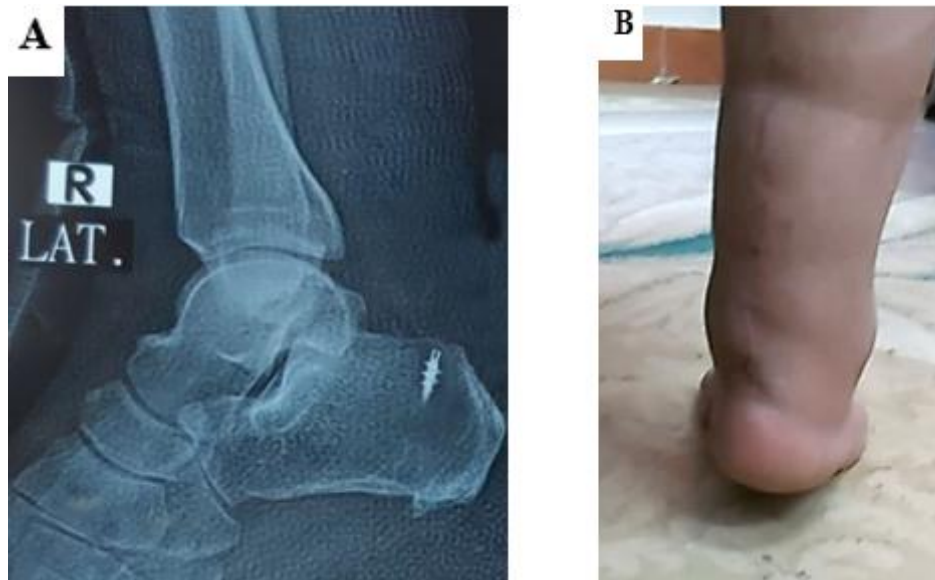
A: Postoperative X-ray shows excision of the Haglund bony prominence and proper positioning of the titanium anchor. B: One year postoperative with proper wound healing and adequate single-leg heel rising.
